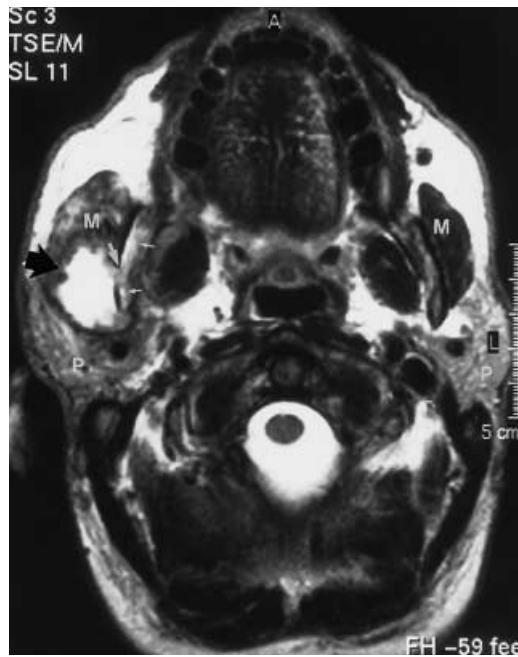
Axial turbo spin-echo T2-weighted MR image of the midface shows the extraosseous extension of the mass within the right masseter muscle (*black arrow*), appearing heterogeneous and hyperintense on T2-weighted images. The *white arrow* shows the destruction of the lateral cortical mandible. Note the hyperintense areas within the right mandibular cavity (*small white arrows*). *M* masseter muscle; *P* parotid gland; *L* left; *A* anterior
